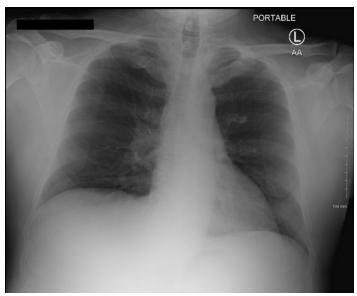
Portable chest radiograph of a 57-year-old male veteran with recurrent fevers.
